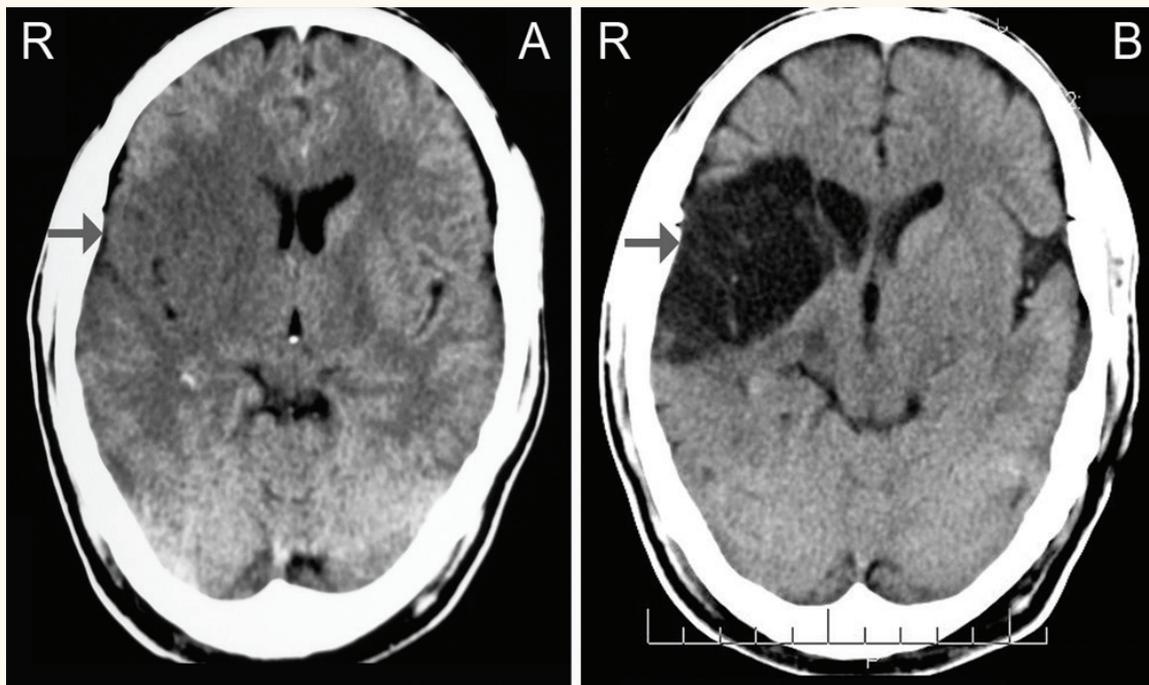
A: Cranial computed tomography scan obtained on the day of the stroke demonstrates ill-defined hypodensity (arrow pointing to the low signal) in the right fronto-parieto-temporal region, corona radiate and capsulo-ganglionic area consistent with a recent infarct in the distribution of right middle cerebral artery. B: The lesion is well delineated with a density similar to that of cerebrospinal fluid (arrow) along with dilatation of ipsilateral ventricle in the scan performed 7 months after the event indicating chronic infarction. Note the absence of an additional lesion in the left hemisphere in both figures A and B.
